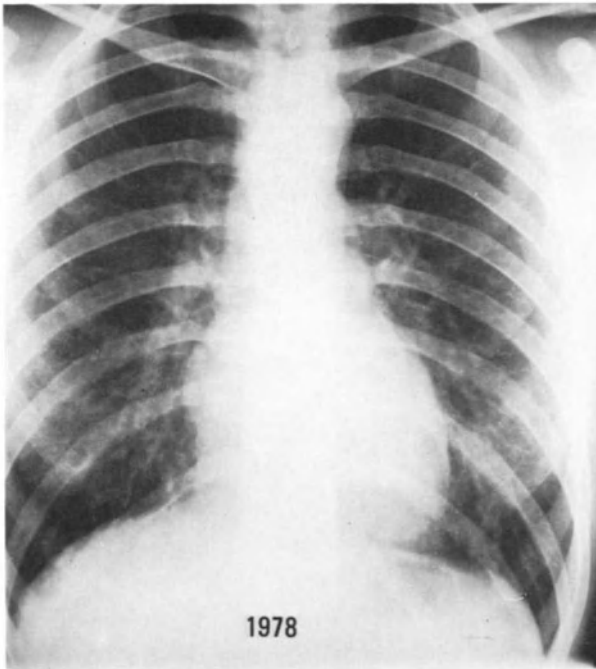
X-ray plate of same patient as in Fig. 6, taken in 1978 and showing state of resolution after surgery, ^{131}I therapy, and thyroxine medication
